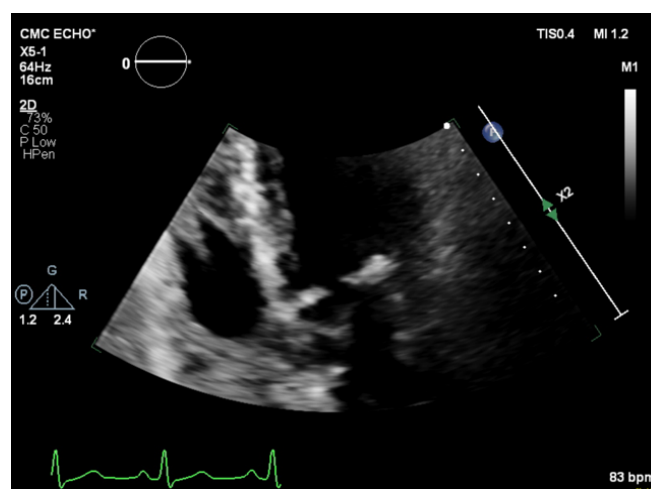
Transthoracic ECHO apical 4-chamber view demonstrating nonspecific thickening of the mitral valve and annular apparatus).
